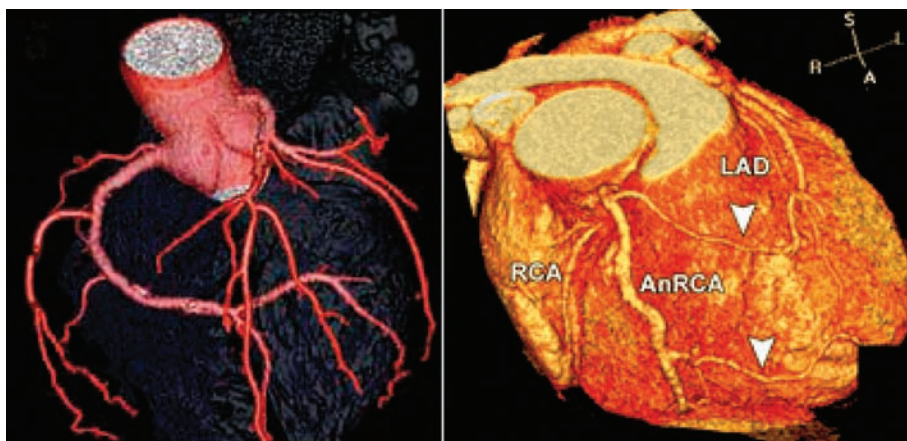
A CT coronary angiogram. A 3D reconstruction of a cardiac CT scan clearly shows the anatomy of the coronary arteries.
